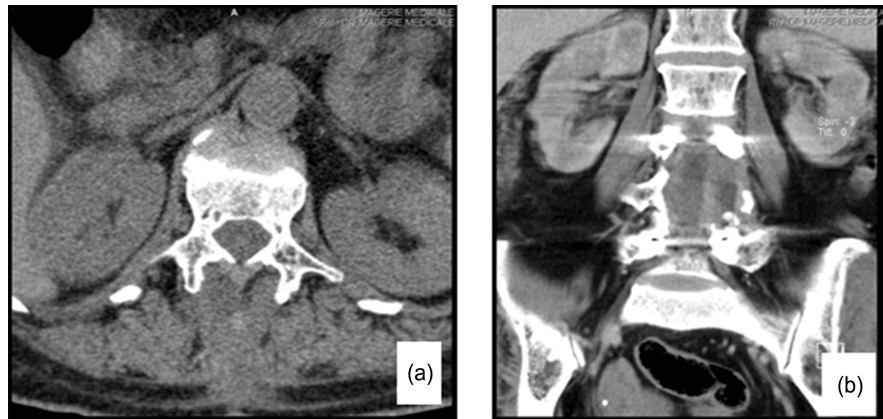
CT image lytic bone lumbar L4 chordoma. (a) Transversal view; (b) Frontal view.
